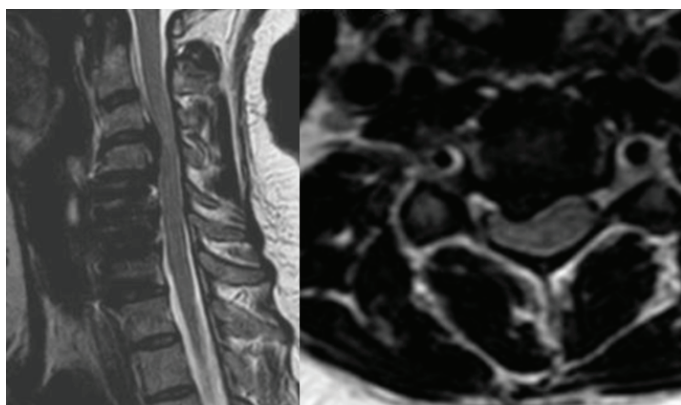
T2-weighted cervical MRI (sagittal left, axial right) shows extruded disc herniations at C3–C4 and C4–C5, with marked spinal canal stenosis and spinal cord compression. Intramedullary T2 hyperintensity indicates myelopathy. There is cervical straightening, early kyphosis, and segmental instability.
